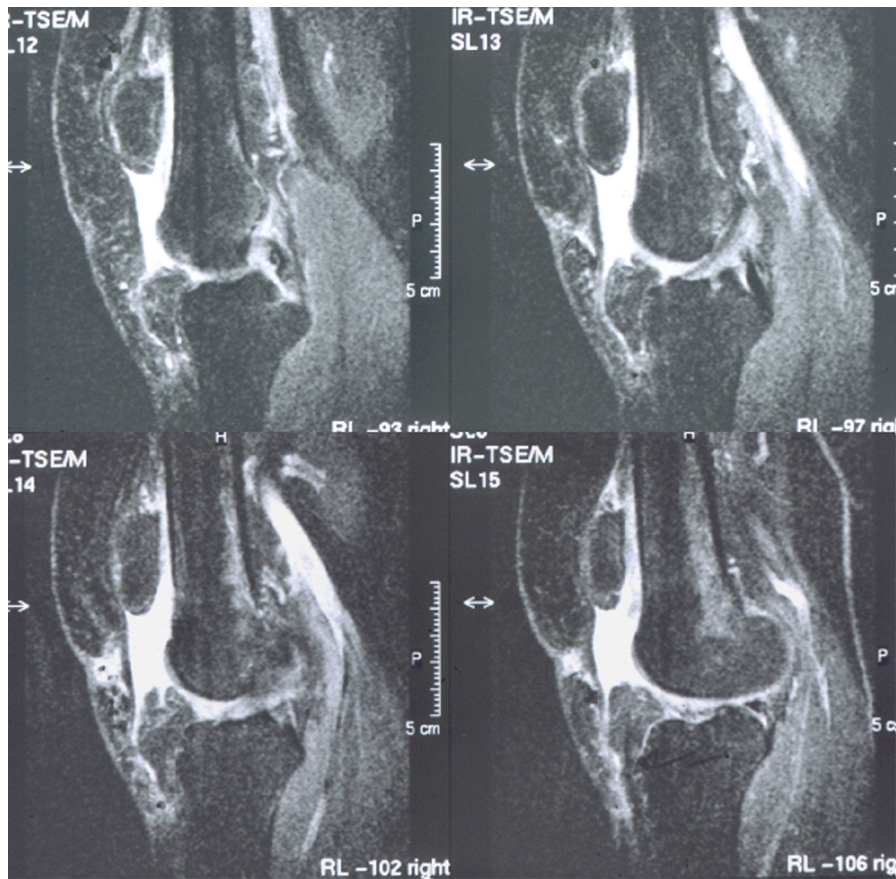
Multiple sagittal MRI views showing the complete patellar tendon rupture and the patella alta.
